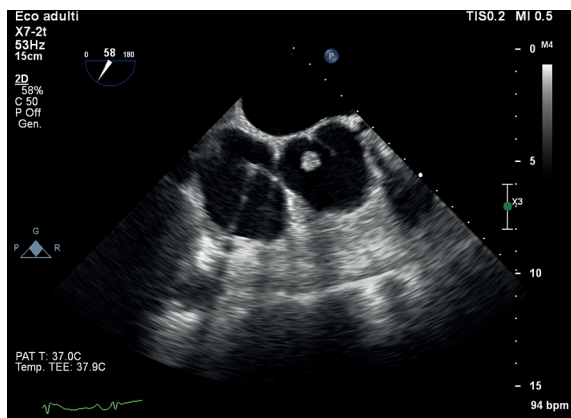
Transesophageal echocardiography: valvular vegetation adherent to the non-coronary cusp of the aortic valve.
